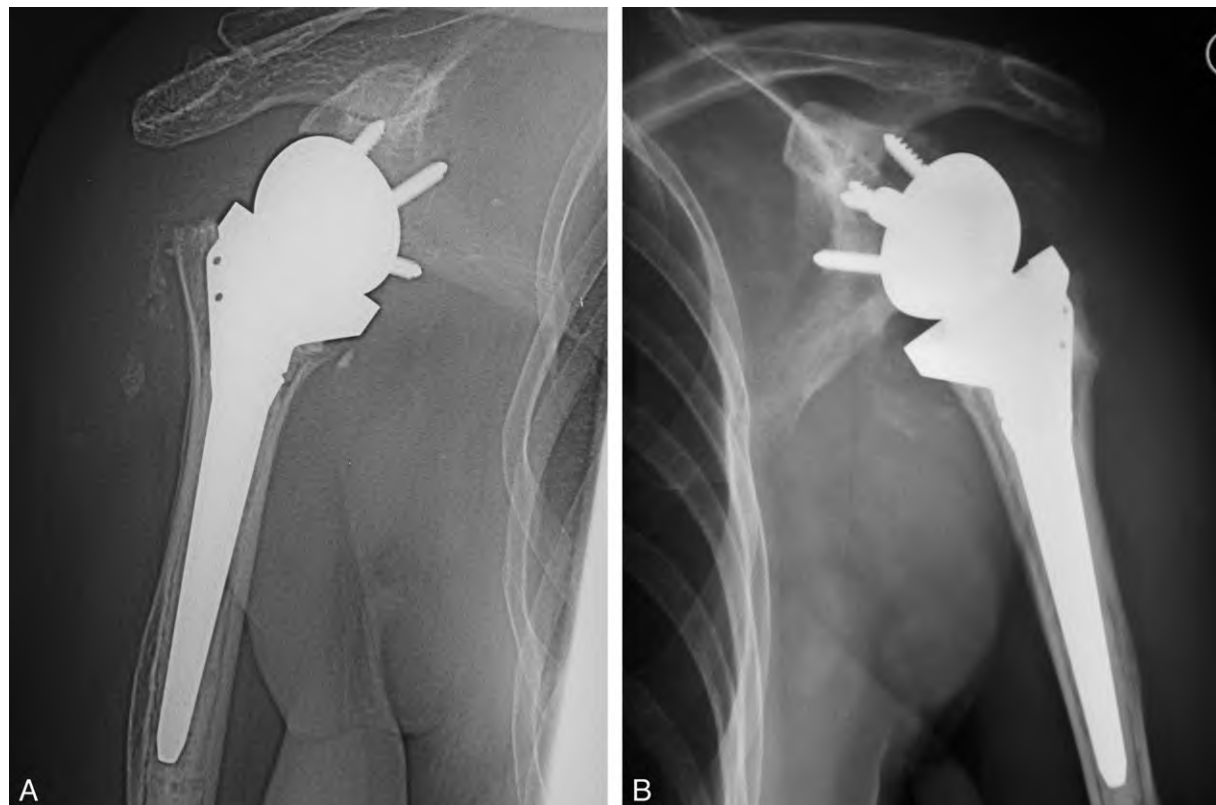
Postoperative radiographs demonstrating intact prostheses of right (A) and left (B) shoulders.
